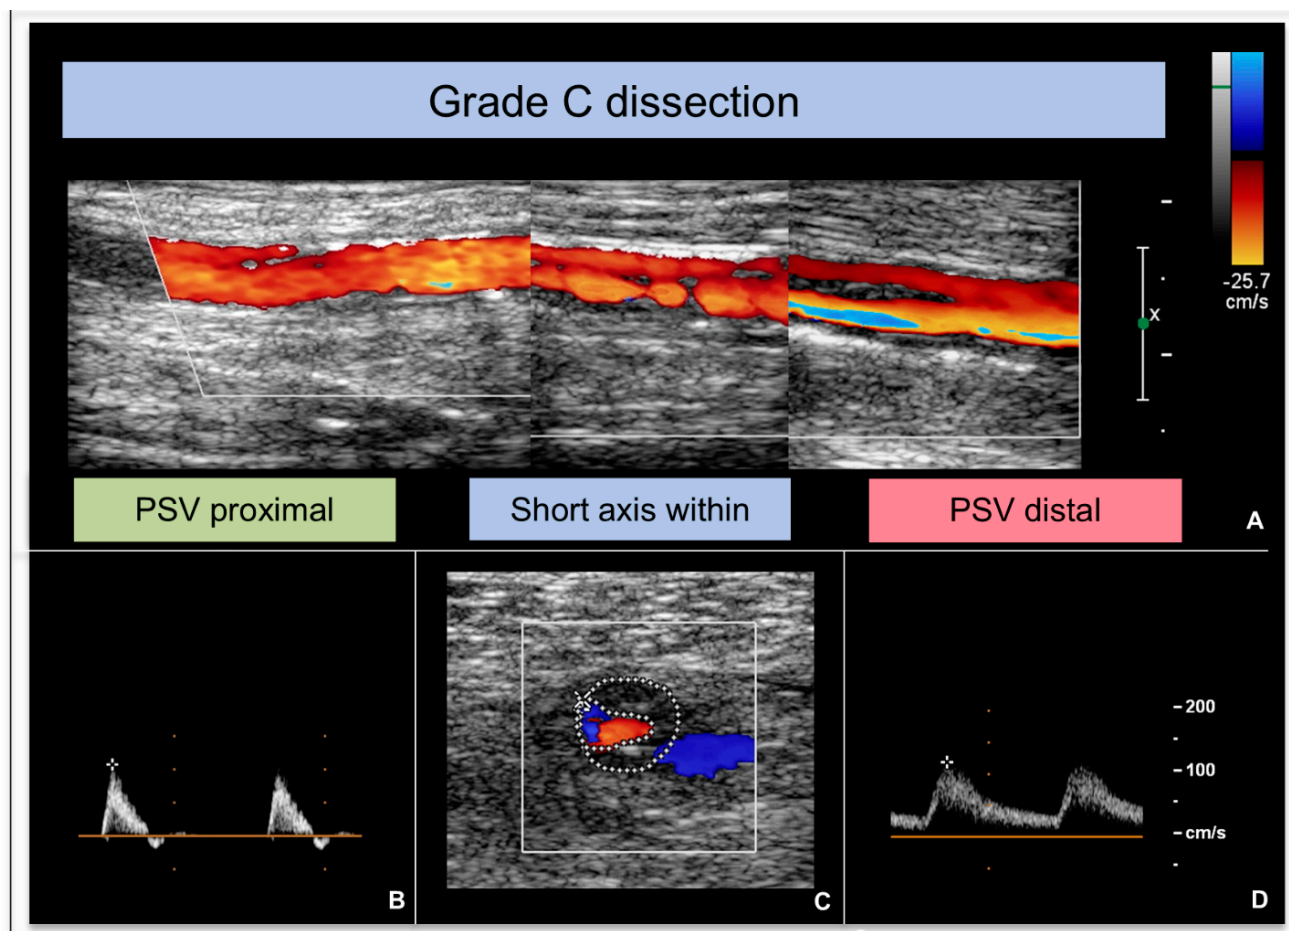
Example of intraoperative DUS assessment of grade C dissection that occurred after PTA. (A,C) Bi-dimensional images of dissection captured by DUS in long- and short-axis views, respectively. (B) Normal spectral Doppler proximal to dissection. (D) Abnormal spectral Doppler distal to dissection. After DUS assessment, it was deemed necessary to optimize PTA result. DUS = Doppler ultrasound. PSV = peak systolic velocity. PTA = percutaneous transluminal angioplasty.
